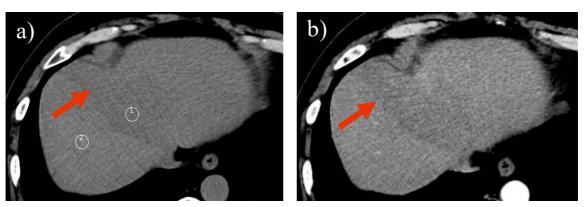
左葉の区域性脂肪肝 (a)単純 CT (b)動脈相 CT
